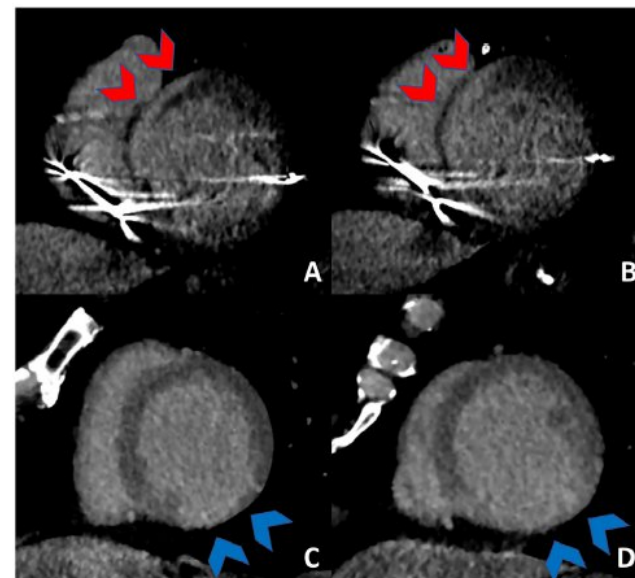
Non-ischemic and ischemic myocardial scar patterns defined by CT. Myocardial fibrosis with non-ischemic pattern at basal septum is well evident in panel A and B at late-phase post-contrast CT images; similarly, in a different subject (panel C and D), an ischemic pattern of infero-posterolateral wall fibrosis was identified with CT. Myocardial fibrosis at CT is defined by identification of hyperdense area into left ventricle wall ($>6SD$ from HU at remote myocardium) and/or myocardial thinning (less than 5 mm of thickness).
